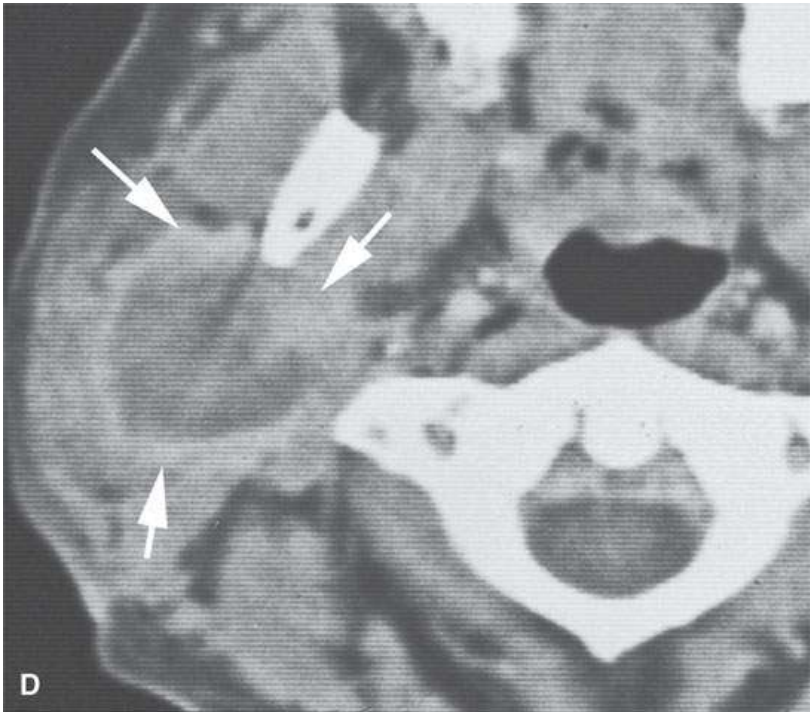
Contrast-enhanced computed tomography of a well-circumscribed parapharyngeal monomorphic adenoma (A, B) and a monomorphic adenoma (C, D) with more aggressive margins (arrows). Both were benign.
